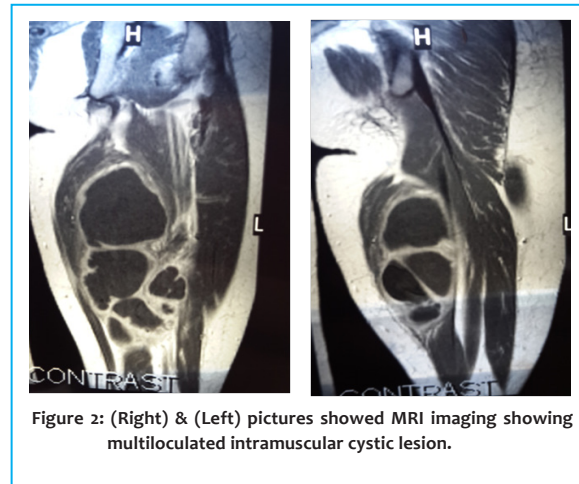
(Right) & (Left) pictures showed MRI imaging showing multiloculated intramuscular cystic lesion.
